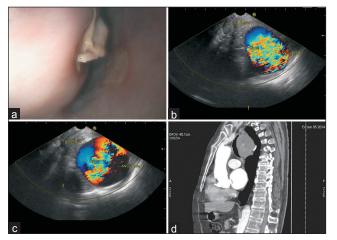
(a) Bulging aneurysm compressing the esophagus with overlying ulcer (b) Endoscopic ultrasound (EUS) image of aneurysm (c) EUS image of aneurysm with thrombus at the level of arch (d) Computed tomography (CT) scan showing thrombus and dissection
